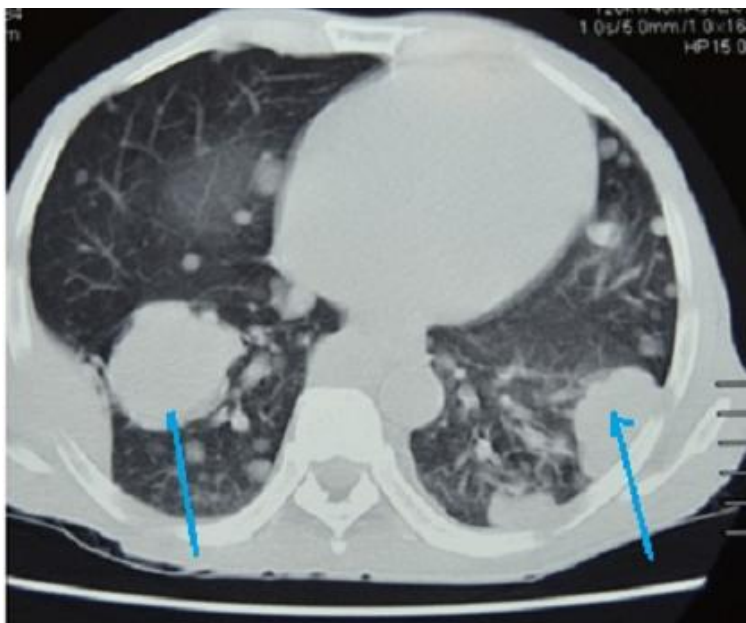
chest CT Scan of showing lung masses (blue arrows) and multiple nodules consistent with metastatic lung disease from Hepatocellular carcinoma
